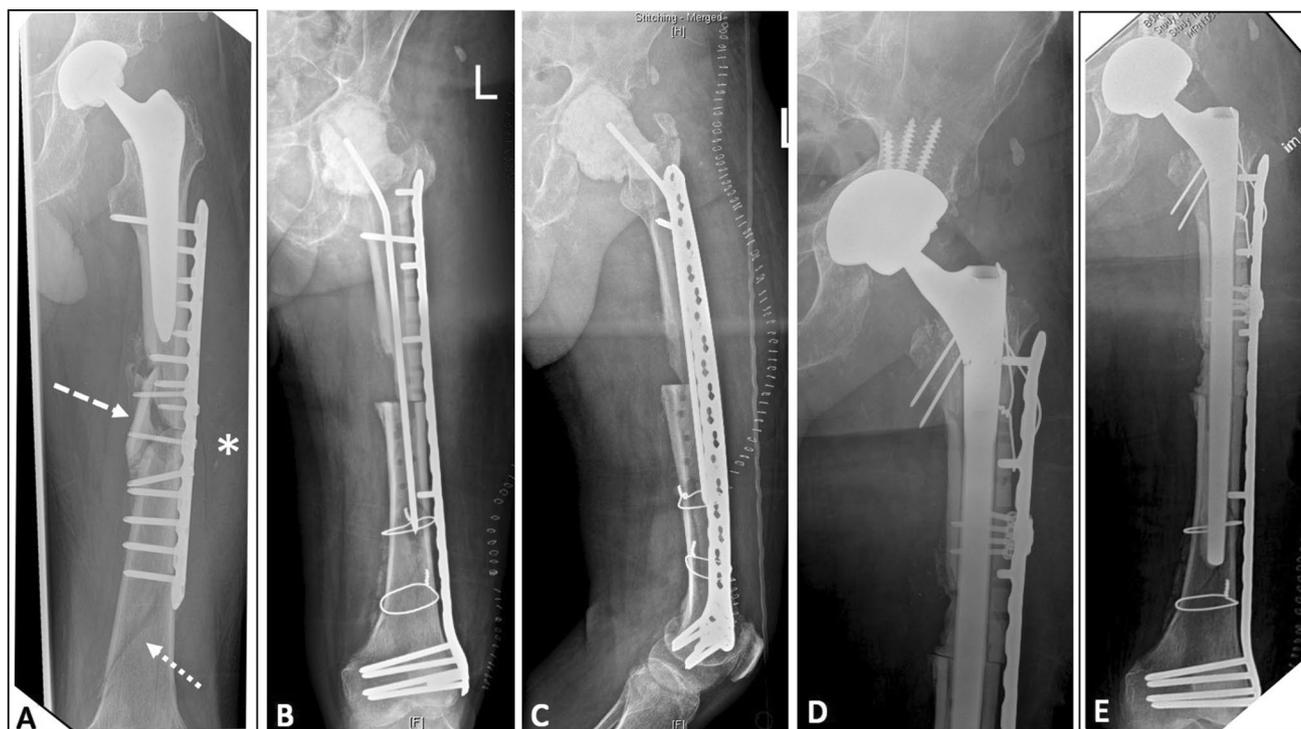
The X-rays of case 1. a Periprosthetic femoral fracture Vancouver C, which was initially treated with a plate osteosynthesis in another hospital. Dotted arrow: distal femoral fracture, additionally suffered shortly before transfer to our hospital, dashed arrow: initial periprosthetic fracture (due to a traffic accident) with a single avital
